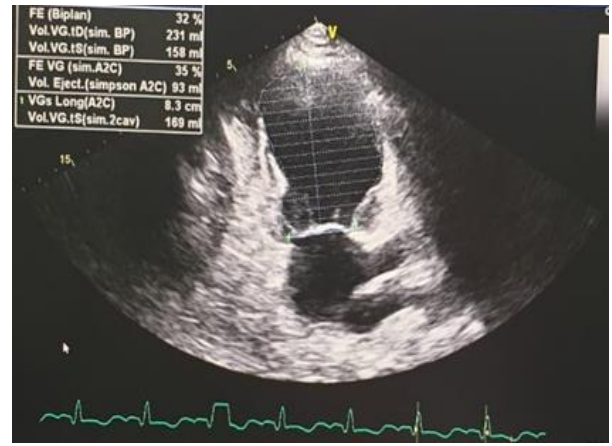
Transthoracic echocardiography two chamber view showing the ventricular apical aneurysm.
